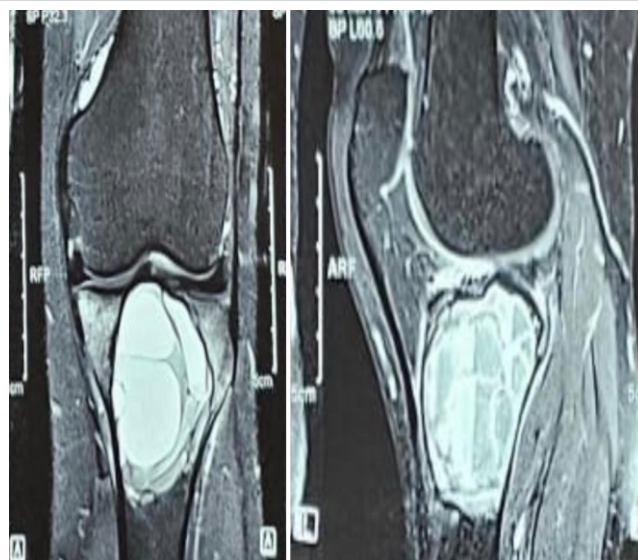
Pre-operative magnetic resonance imaging T2- weighted images of the knee showing a hyperintense lesion in the proximal tibia with fluid-fluid levels.
